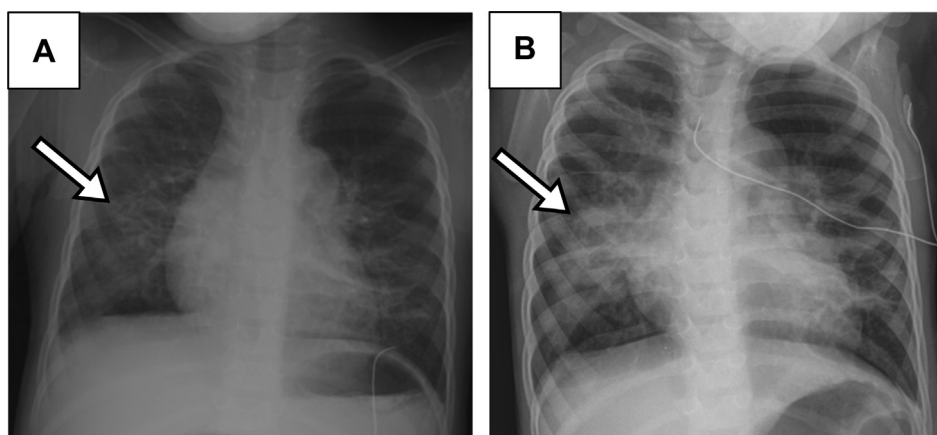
Comparative chest radiographs (CXRs) of a 2-year-old premature girl with human metapneumovirus (HMPV) infection. (A) Initial CXR during admission to the hospital due to HMPV infection showing a focal infiltrate in the right lower lobe (arrow); (B) 48 hours later CXR shows progression of right lower lung opacities (arrow) that correlated with worsening of crackles, poor air entry, respiratory distress, and hypoxemia.
